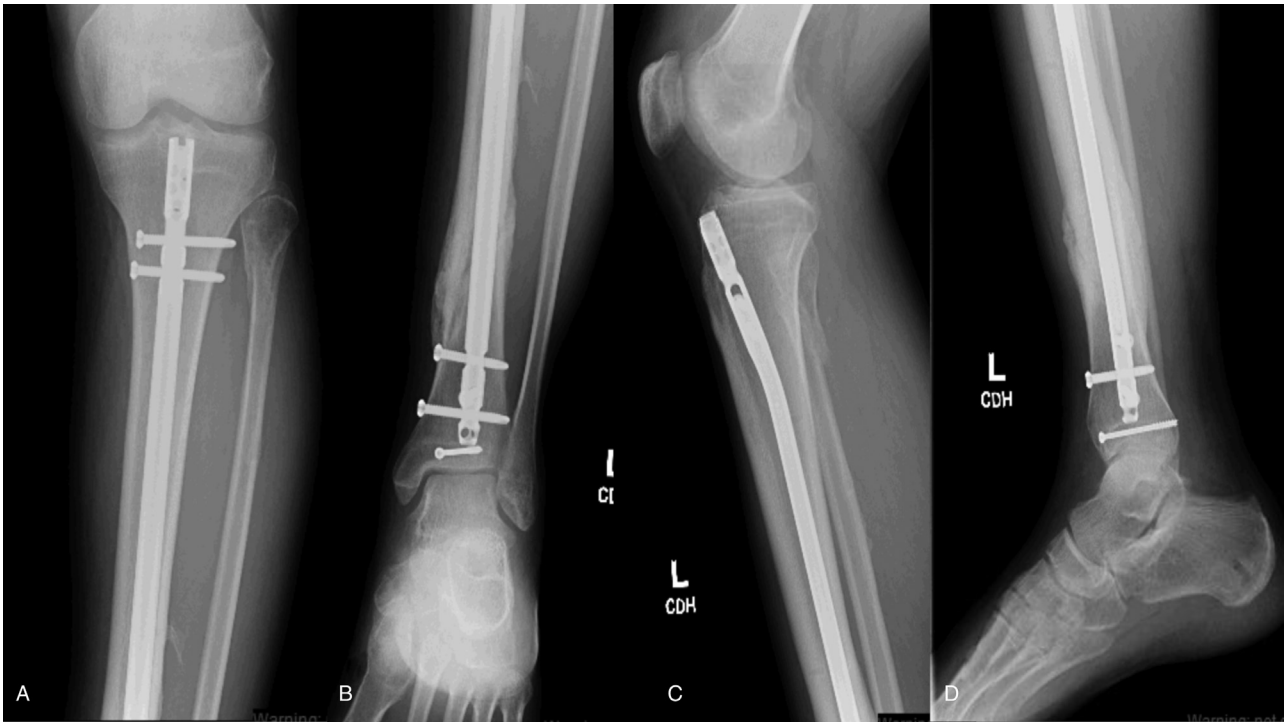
(A–D) Anteroposterior (A, B) and lateral (C, D) radiographs of the left tibia 6 months postoperatively following intramedullary nailing of diaphyseal tibia fracture, percutaneous screw fixation of posterior malleolar fracture, and closed management of proximal fibula fracture. Interval callus is observed about all 4 cortices consistent with fracture union.
